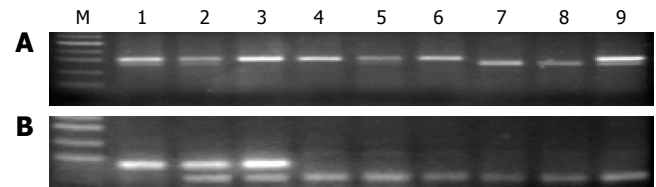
A: *Hinf* I distinguishes MTHFR 677 (C→T) PCR products. M: 50 bp Ladder; L1, 2, 5 and 9: CT genotype; L3, 4 and 6: CC genotype; L7 and 8: TT genotype; B: *Mbo* II distinguishes MTHFR (A→C) PCR products. M: 50 bp ladder; L1: CC genotype; L2 and 3: AC genotype; L4-9: AA genotype.
